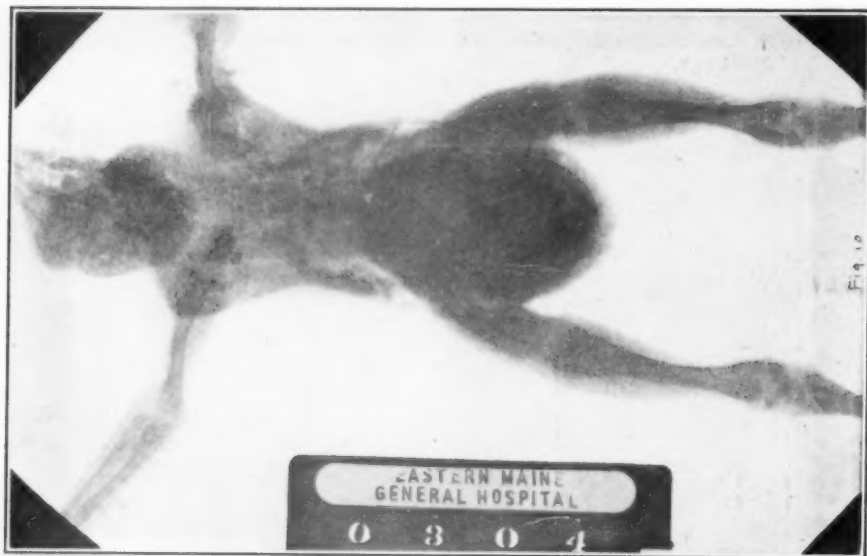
A roentgenograph of the smaller chicken in Fig. 2.
